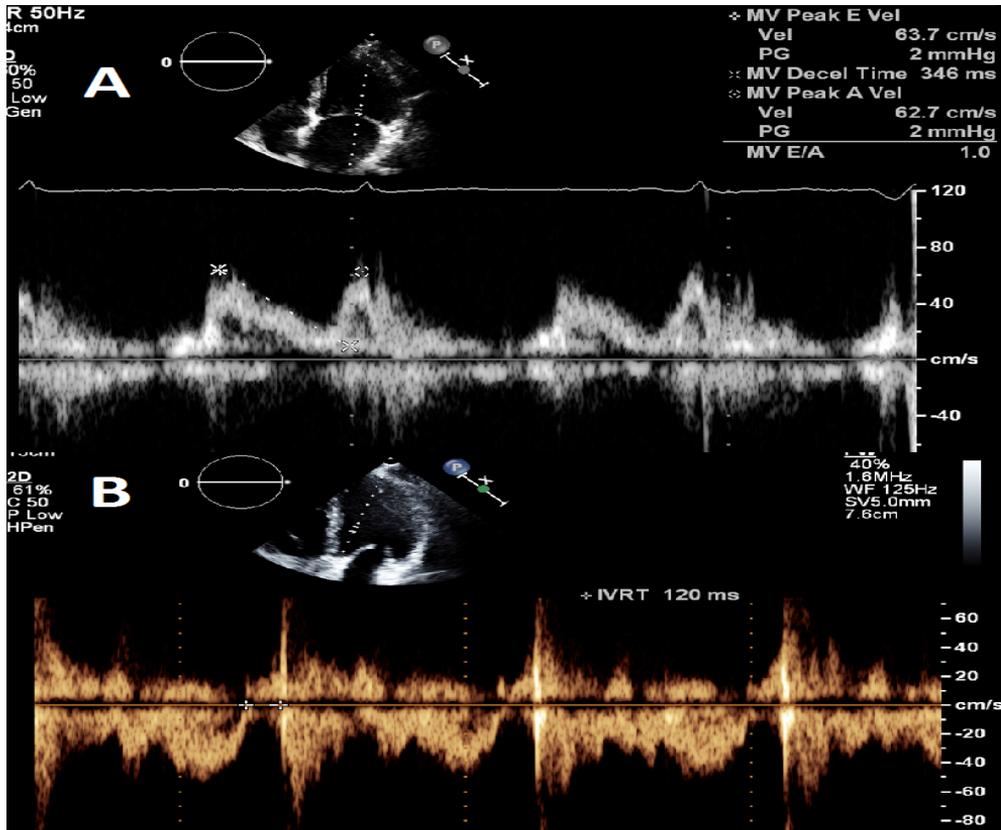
Measurements of left ventricular diastole in echocardiography. Mitral inflow measurements are displayed in figure 7A. The measurements are taken at the mitral valve opening level. The first part of the mitral inflow (E-wave) and its length (dt, declaration time) are directly related to left ventricles active relaxation properties. The A-wave is created by active atrial contraction in patients with sinus rhythm. In figure 7B measurement of isovolumetric relaxation time (IVRT) is displayed. The measurement is taken at the midpoint between mitral valve and left ventricular outflow track from closing signal of aortic flow to opening signal of the mitral valve inflow. All diastolic measurements are taken at the end-expirium and with pulsed Doppler.
